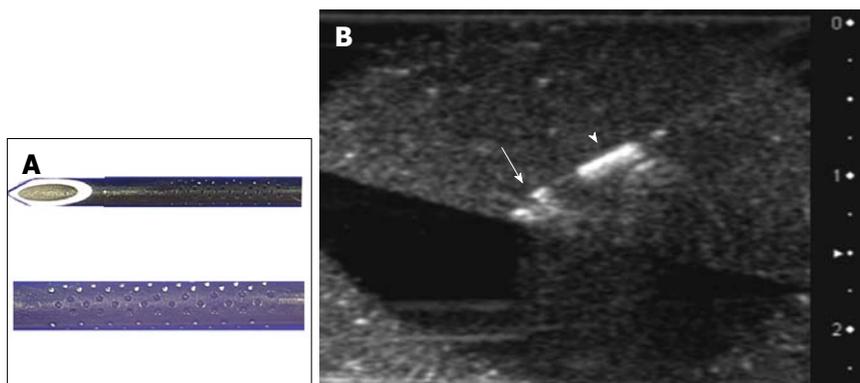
Vascular needle with dimples placed at 5-8 mm from the tip (dimple needle). A: Needle tip, shaft; B: Corresponding ultrasound image, with the dimples indicated by the arrowhead and the needle tip indicated by the arrow.
